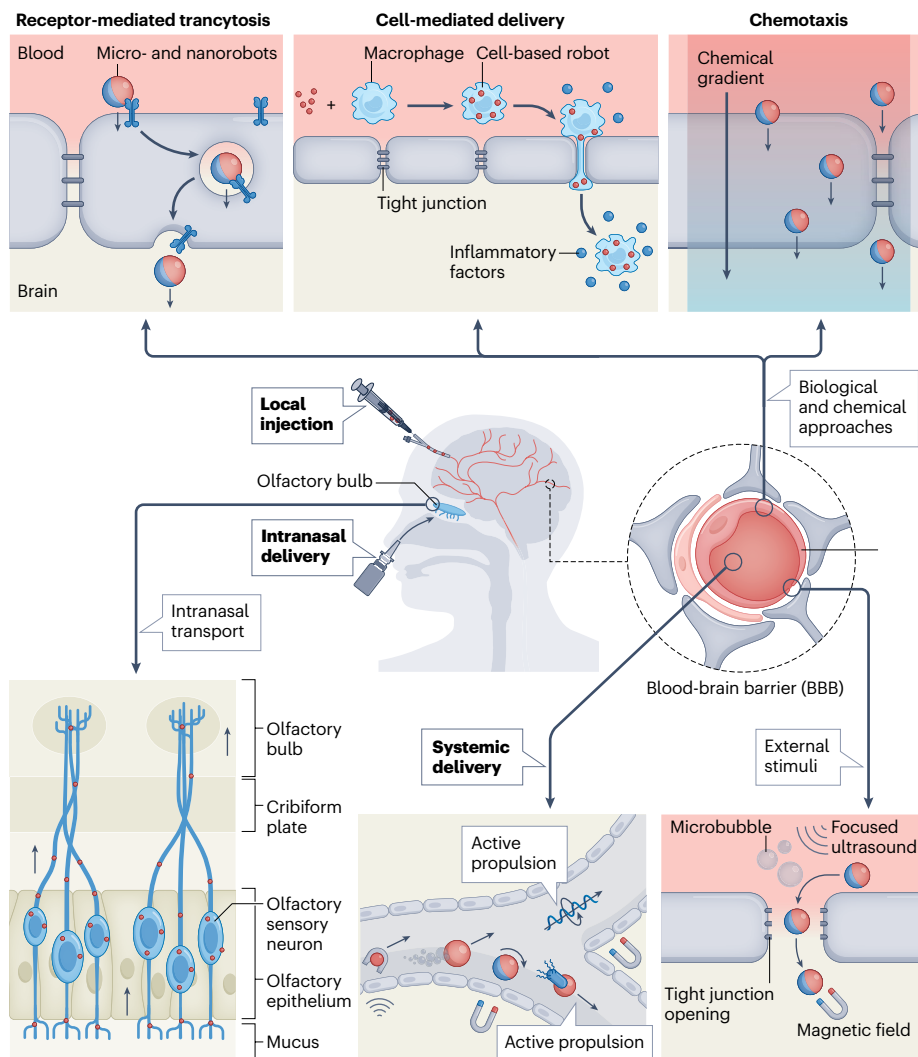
Strategies to introduce micro- and nanorobots into the brain for drug and cell delivery. Local injection, intranasal transport and systemic delivery. The penetration of the BBB and the efficiency of systemic delivery can be improved using biological and chemical approaches (for example, receptor-mediated transcytosis, cell-mediated delivery and chemotaxis) and external physical stimuli (such as focused ultrasound and magnetic field), along with the active propulsion of micro- and nanorobots.
